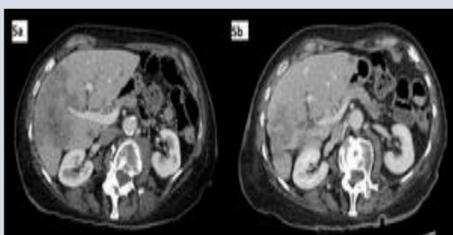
Axial contrast enhanced CT with multiple low attenuation liver metastases in a patient with breast cancer prior to chemotherapy. Fig 1b. Follow up CT performed 5 months later demonstrating chemotherapy induced pseudocirrhotic changes.
